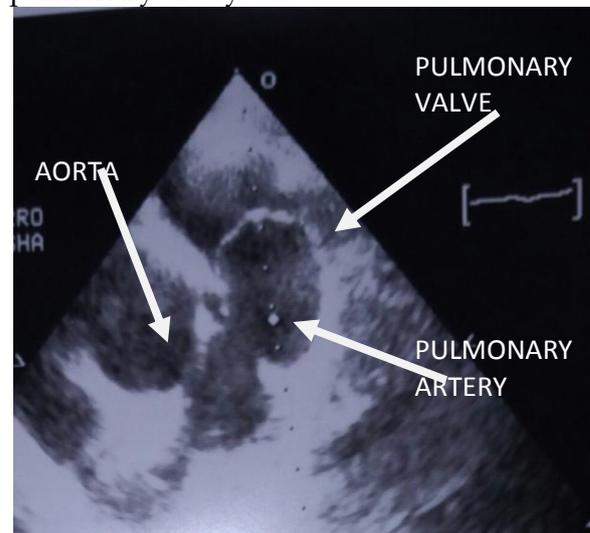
Short axis view echocardiogram at the base of the heart at aortic valve level. Arrow indicating thickened and stenosed pulmonary artery valve
